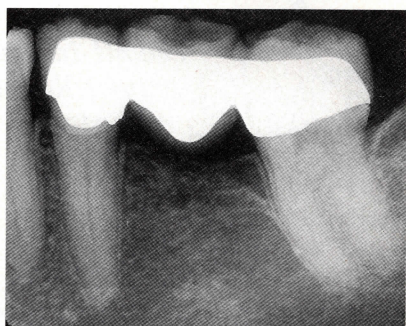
Postorthodontic radiograph of lower left quadrant, showing the restoration of parallelism to abutment teeth, provision for pontic placement, and dramatic repair to the angular crest (compare to Figure 4E), as well as the elective extraction of the third molar, and restoration with a three-unit bridge. (Restoration by Dr. Jonathan Zamzok, New York, NY.)
